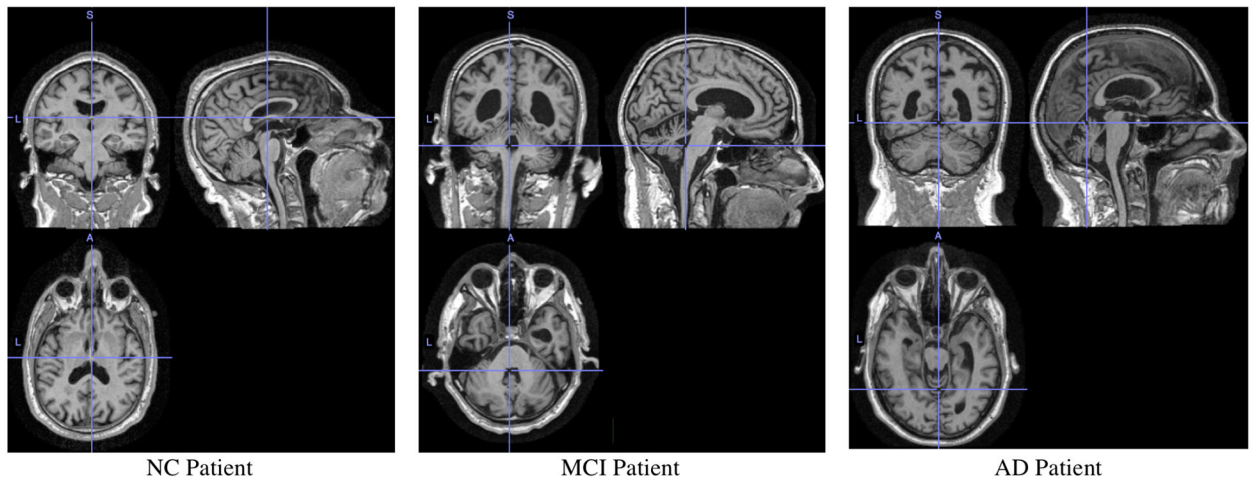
MRI of an NC, MCI, an AD patient.
